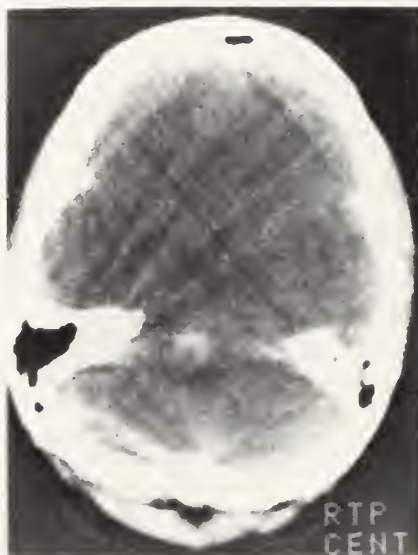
Unenhanced CT of Case 2 showing blood density in the region of the right dorsolateral pons.
